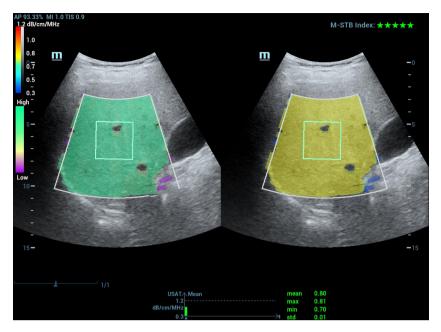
Actual measurement screen of an USAT. USAT, ultrasound attenuation analysis; std, standard deviation; AP, acoustic power; MI, mechanical index; M-STB, motion-stability.
